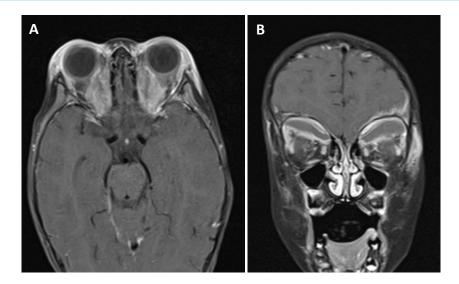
T1 weighted fat suppressed gadolinium-enhanced MRI sequences of the (A) axial and (B) coronal planes of the head and orbits showing rim enhancing spindle-shaped predominantly hypointense masses occupying the superior extraconal regions of both orbits.
